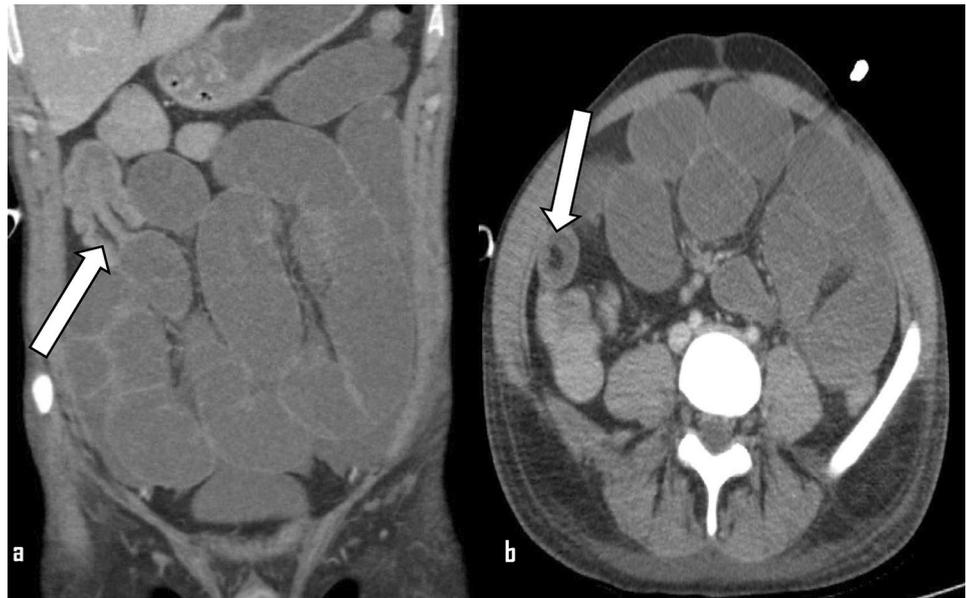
Axial (a) and coronal (b) unenhanced CT of 24-year-old male with right lower quadrant pain showing fecalised content and distension of the distal ileum in keeping with DIOS
